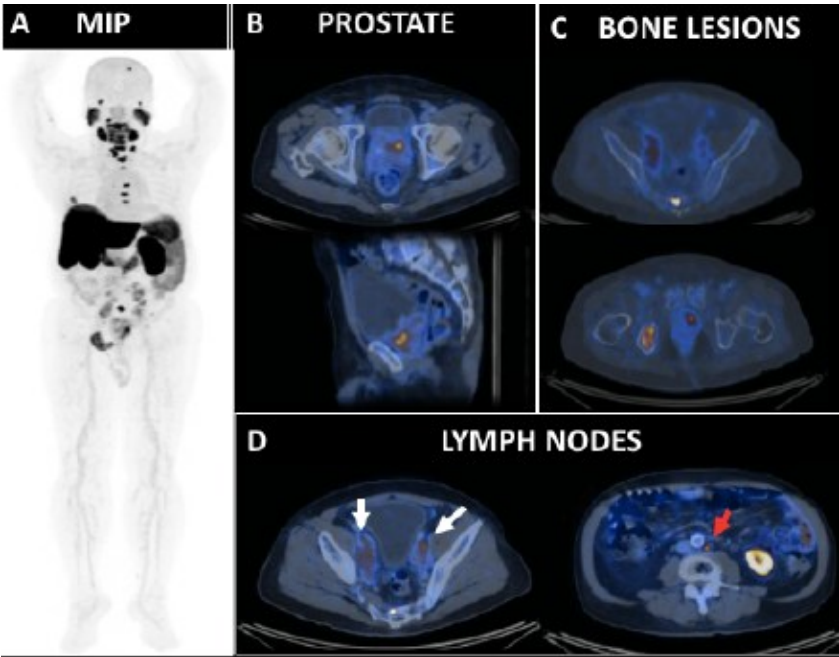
Baseline 18F-PSMA PET/CT performed for staging of known primary prostate carcinoma.
